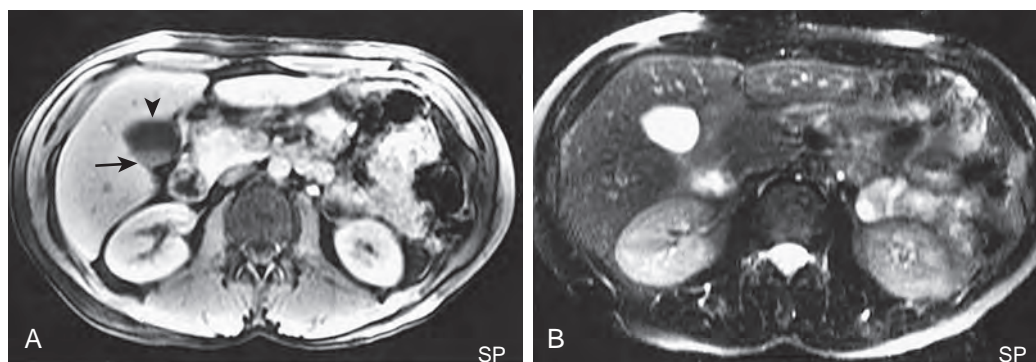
Normal gallbladder: MRI. A. T1-weighted fat suppression image shows high signal intensity, concentrated bile in the dependent portion of the gallbladder (arrow) and low signal intensity, less concentrated bile in the nondependent portion of the gallbladder (arrowhead). B. T2-weighted fat suppression image depicts bile in the gallbladder as high signal intensity.
